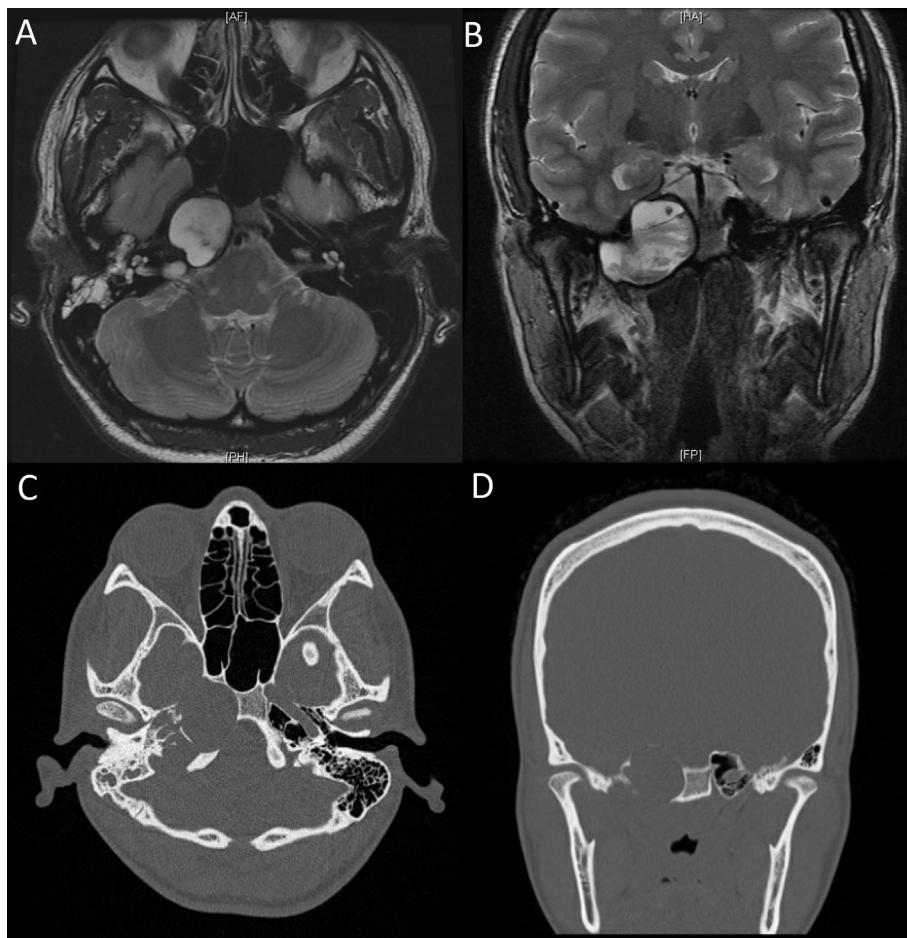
A and B are T2-weighted MRI images demonstrating a multilobulated expansile lesion in the right petrous temporal bone extending to the sphenoid bone and displacing the petrous internal carotid artery consistent with a cholesterol granuloma. C and D are non-contrast high-resolution CT images re-demonstrating the right petrous apex lesion and the associated remodeling and scalloping of surrounding bones including the clivus as well as bony dehiscence of the right petrous carotid canal.
